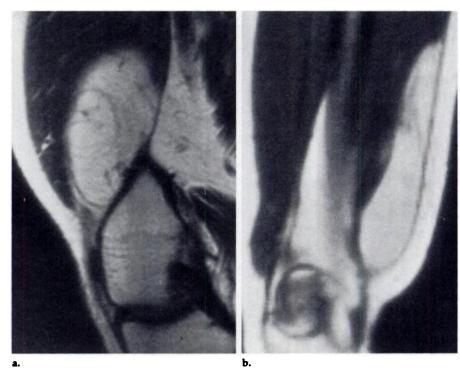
(a) Parasagittal MR image (SE, 800/20) of a knee in a 38-year-old man with a 9-cm suprapatellar lipoma deep to the quadriceps. Margins are smooth, but signal intensity is inhomogeneous. An incorrect MR imaging diagnosis of liposarcoma was made because of the numerous fibrous septa within a tumor that otherwise shows signal intensity characteristic of fat. (b) Coronal MR image (SE, 800/20) of the knee in a 53-year-old woman with a 9-cm-long grade 1 liposarcoma arising medially within the musculus vastus medialis, with smooth margins and a homogeneous but septated appearance. An incorrect MR imaging diagnosis of lipoma was made because of the tumor's homogeneously fatty appearance with all sequences.
